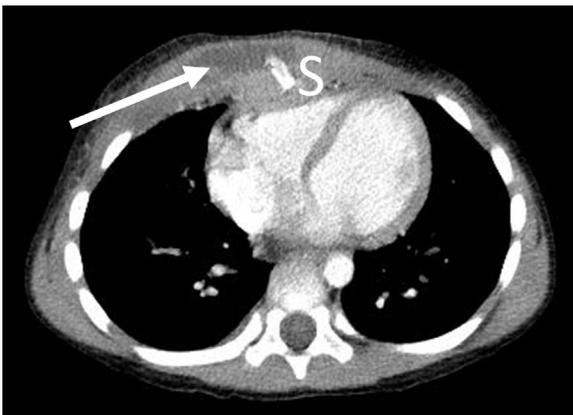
Transverse enhanced computed tomography image showing the sternal fracture (S) and subcutaneous abscess (arrow).
